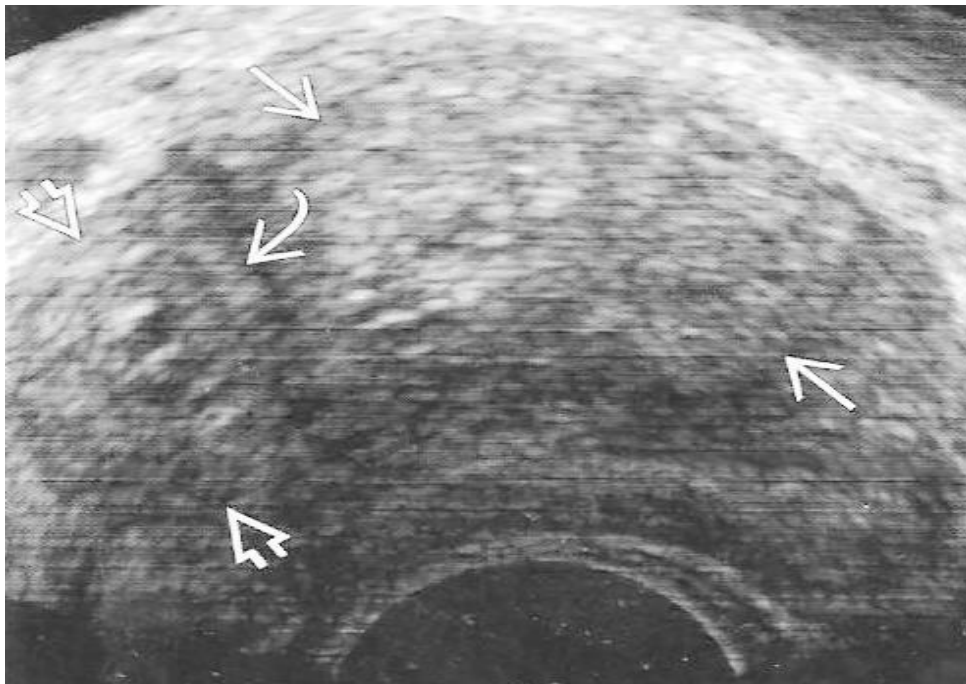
Shows a transrectal ultrasound image of normal prostate
